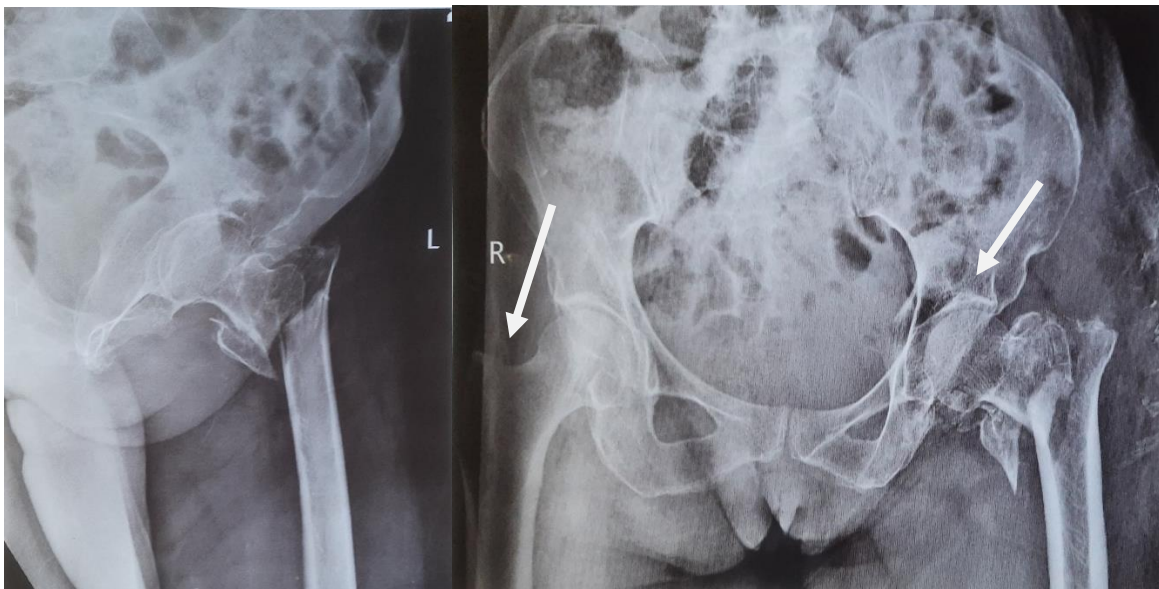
Pre-operative X-ray of Boyd and Griffin type 3 intertrochanteric femur fracture left side.
